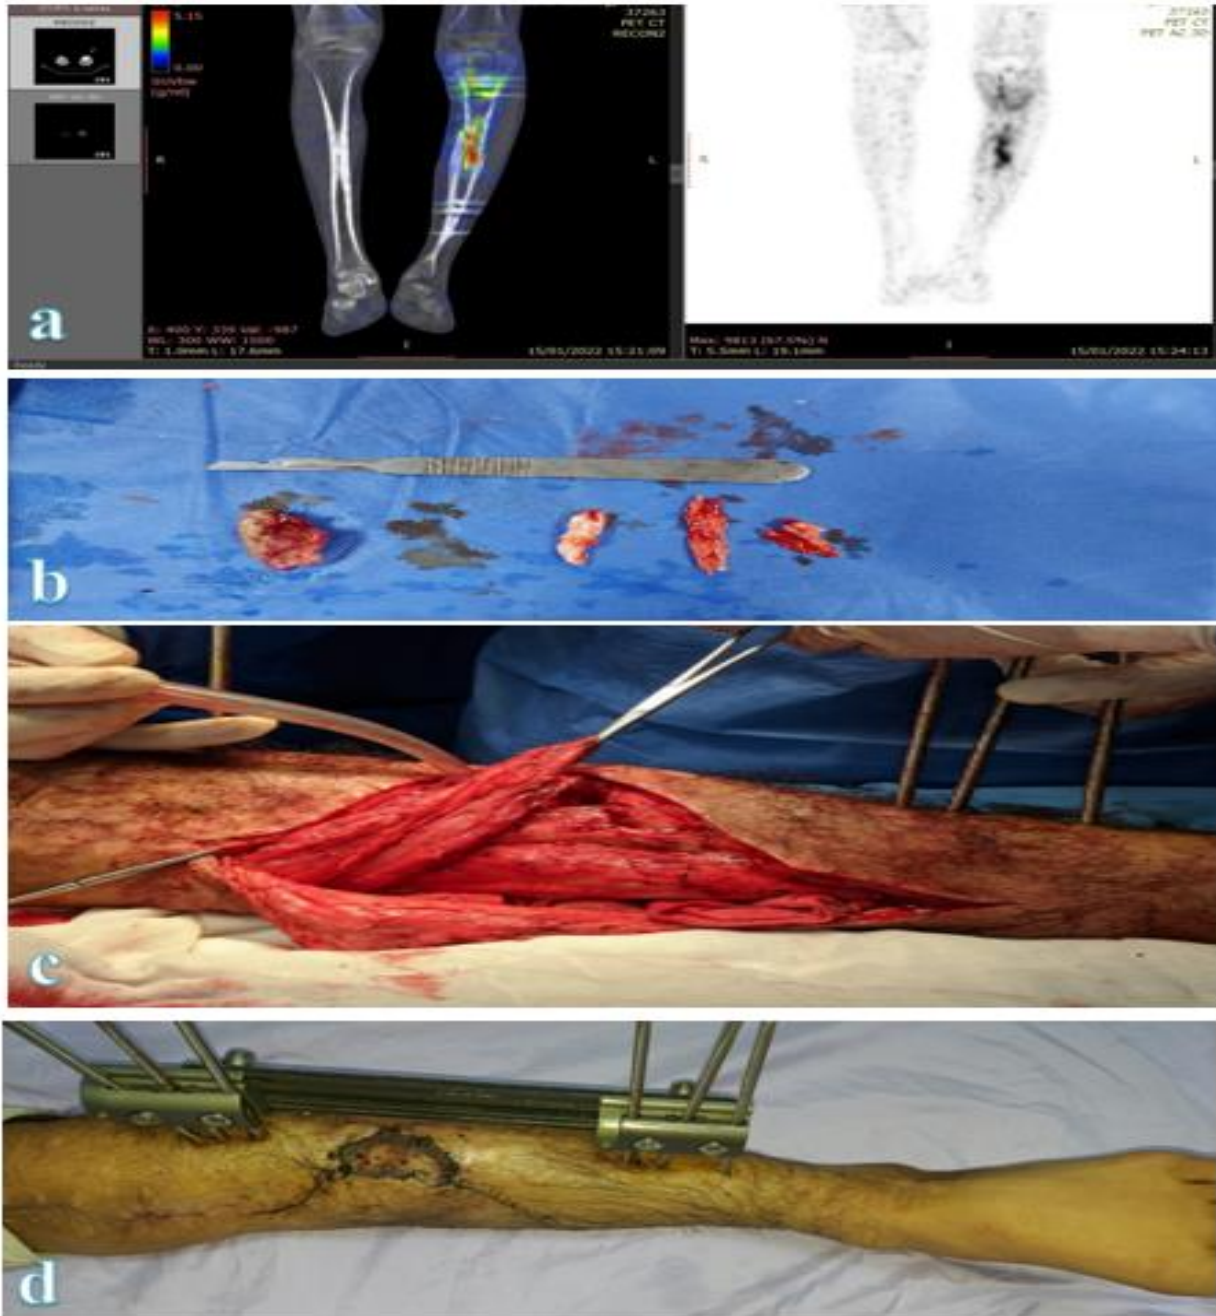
17 years old male patient who presented with compound fracture and osteomyelitis of the left tibia. PET CT scan was done to assess the extent of osteomyelitis. He was managed by bone and soft tissue debridement, polymethyl methacrylate cement insertion and coverage by a medial head Gastrocnemius muscle flap with a skin graft, (a) Pre-operative PET CT scan, (b) Intra-operative bone debridement, (c) Intra operative coverage by a muscle flap, (d) Post-operative clinical photo after 3 months.
